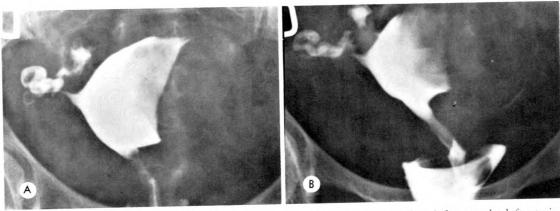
(A and B) Large intramural myoma on the left side: large compression defect on the left uterine wall. (B) The postvoiding roentgenogram shows the appearance of the cervical canal and of the vagina which is slightly deviated to the right.
